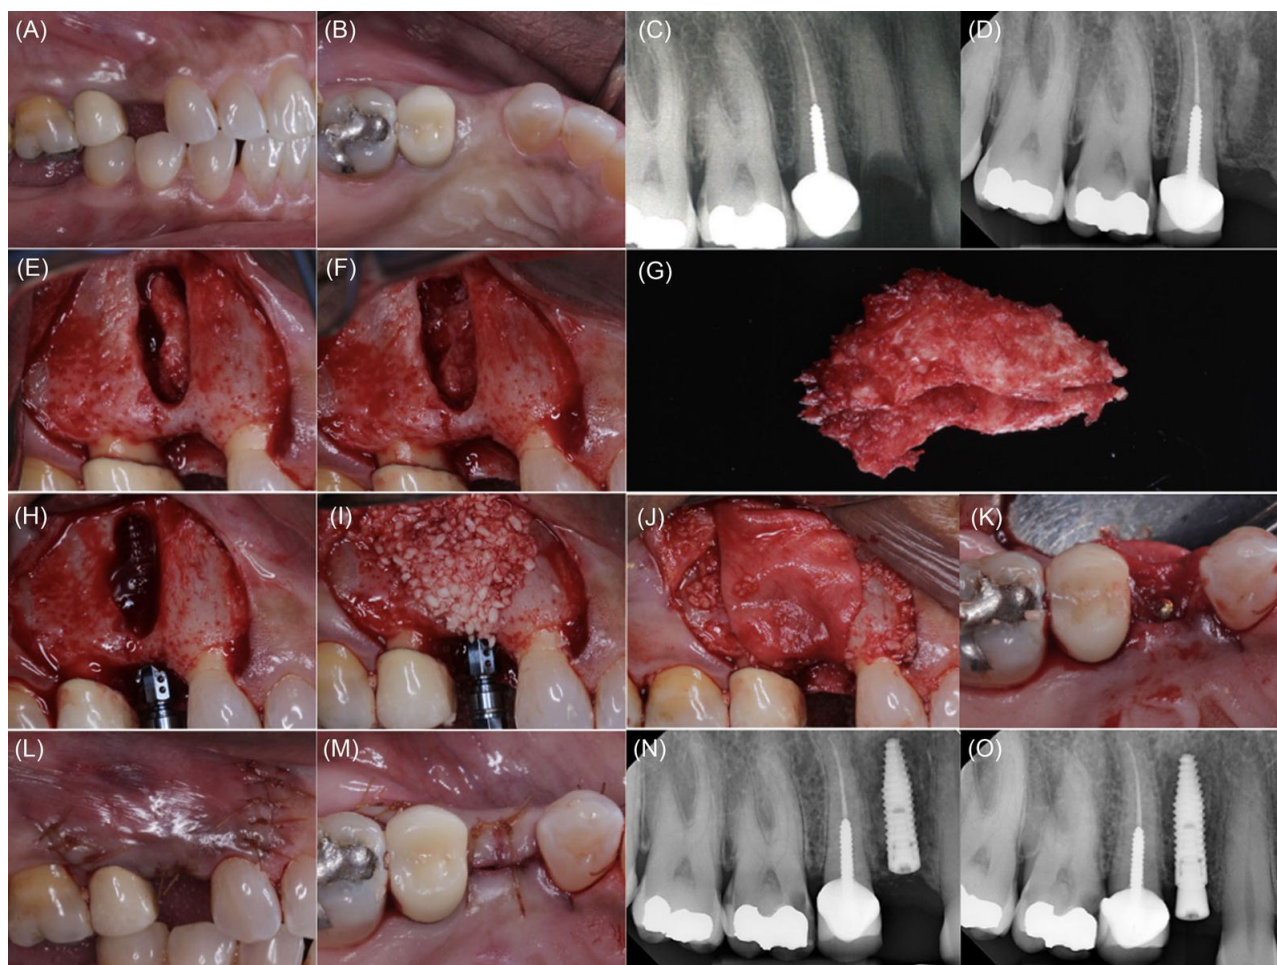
Case 1 with WASRIP. (2a, 2b) Buccal and occlusal view of initial presentation. (2c) Periapical film from general dentist prior to #13 extraction. (2d) Periapical film at initial presentation. (2e) Window preparation and root fragment (RF) identification. (2f) RF removal and degranulation. (2g) RF removed showing fibrous tissue and remnant of particulates from previous procedure. (2h) Osteotomy preparation and implant placement. (2i, 2j) Guided bone regeneration with particulate particles and resorbable membrane. (2k) Resorbable membrane secured with cover screw. (2l, 2m) Flap closure with simple interrupted configuration. (2n) Periapical film immediately after implant placement. (2o) Three-month follow-up and stage 2 surgery.
